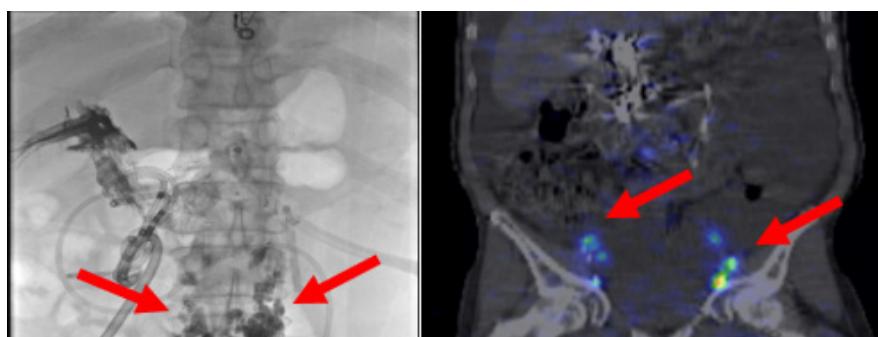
Lymphangiogram and Lymphoscintigraphy.
